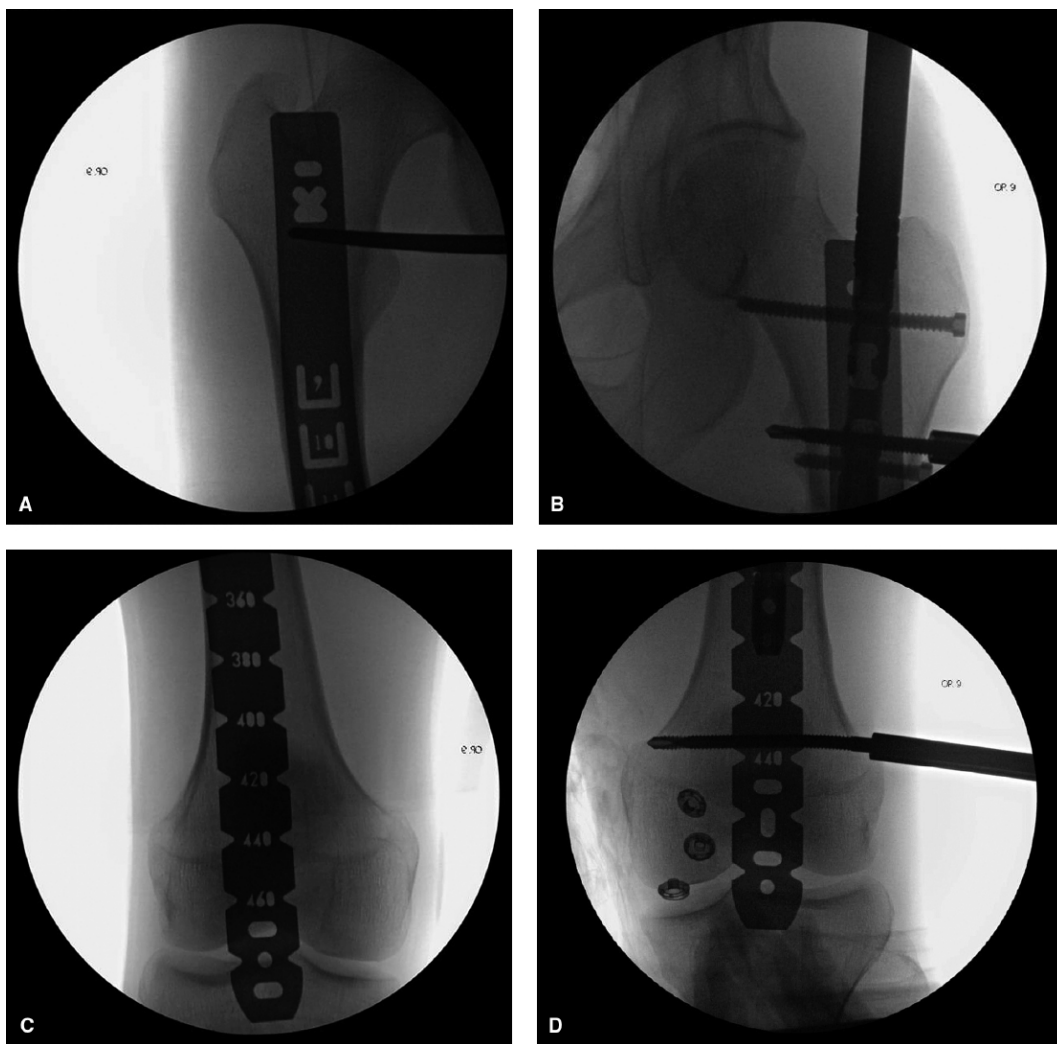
Use of radiographic to assess length. A and B: Proximal edge of ruler placed on same location of bilateral proximal femora. C and D: The same radiographic feature should be used distally. In this patient, using two rulers, the physeal scar of each femur measures 445 mm from the superior aspect of the neck, confirming the anatomic restoration of length.
